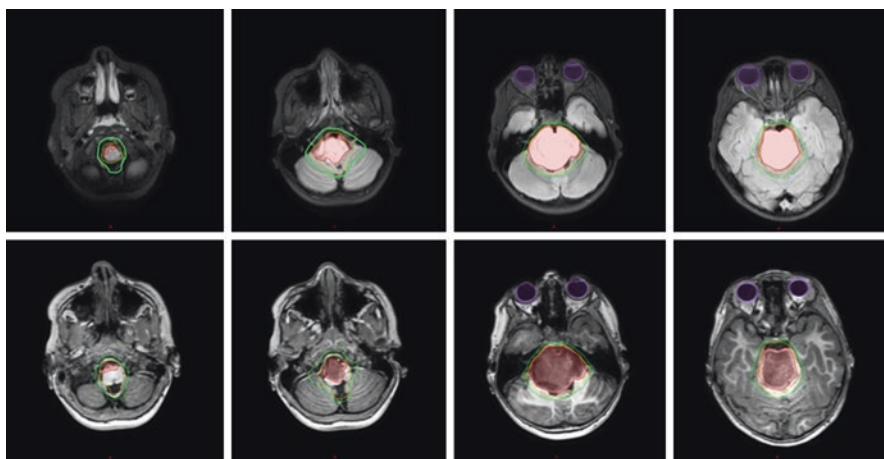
Contours for a patient with a diffuse pontine intrinsic glioma. GTV, red; CTV, yellow; PTV, green. Top row (T2 FLAIR axial MRI sequences); bottom row (T1 3D post-contrast axial MRI sequences)
